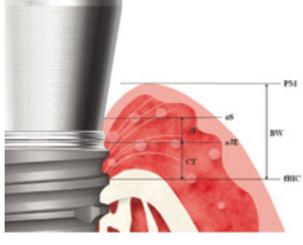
Histometric measurement. PM, marginal portion of mucosa; aS, apical extension of sulcus; aJE, apical portion of junctional epithelium, fBIC, first bone-implant contact; JE, length of junctional epithelium (aS/aJE); CT, length of connective tissue (aJE/fBIC); BW, biologic width (PM/fBIC).
